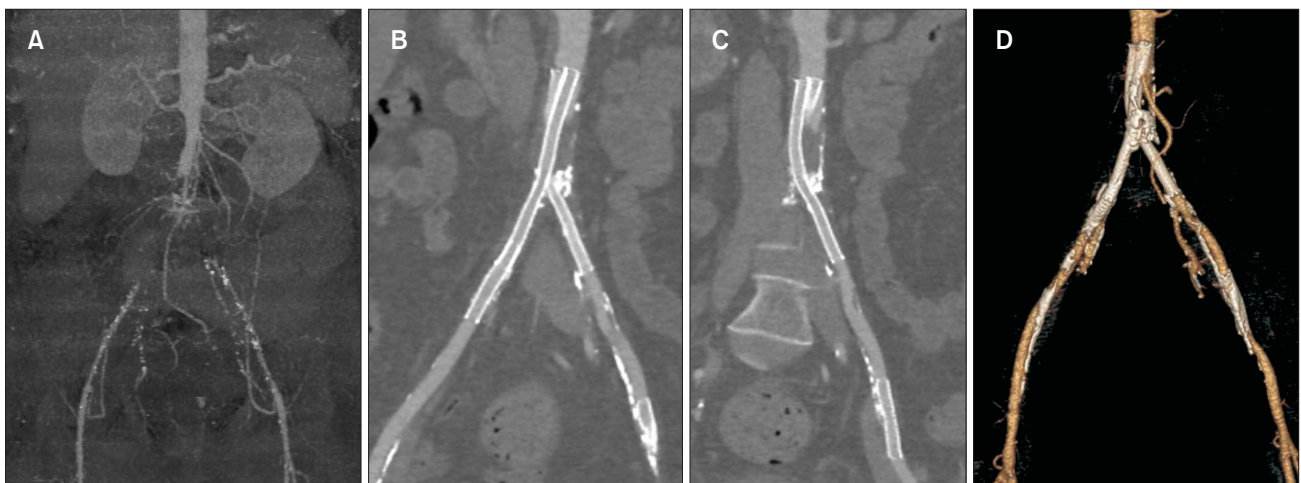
(A) Computed tomography angiography (CTA), coronal maximum intensity projection (MIP) before endovascular recanalization showed total occlusion of the infrarenal aorta and common iliac arteries. Two months later, CTA curved MIP for the right (B) and left lower extremities (C) and three-dimensional reconstruction (D) revealed excellent stent patency without findings of restenosis.
